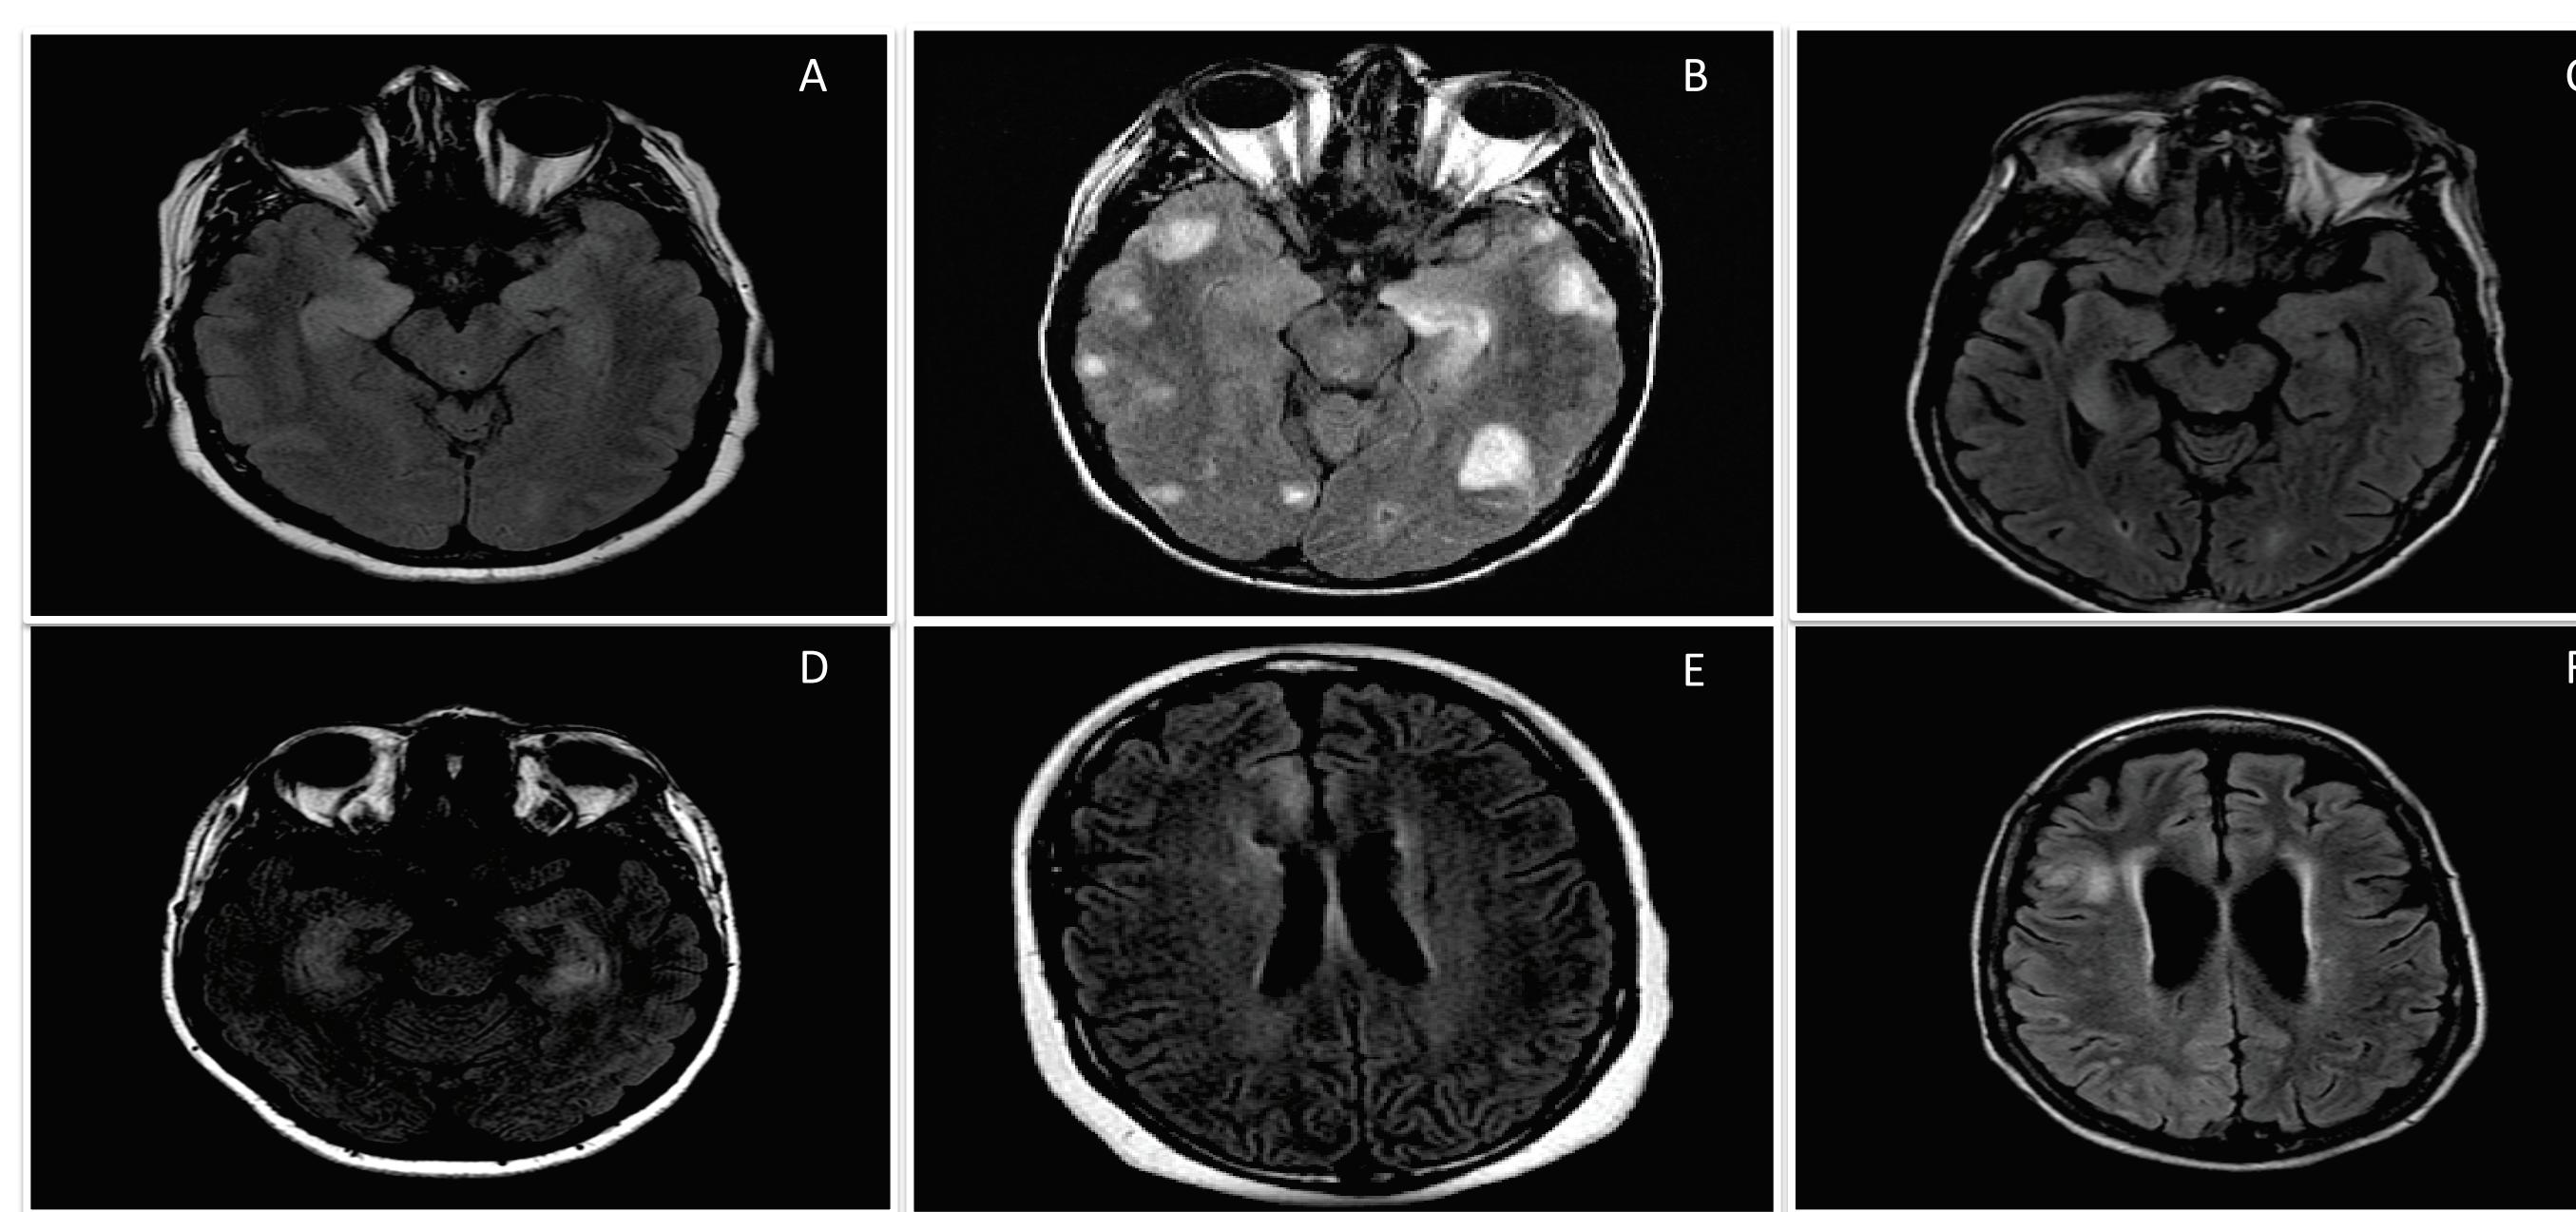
42 yo female with VGKc antibody: MRI showing bilateral temporal FLAIR hyperintensities (A); 43 yo male with VGKc antibody; MRI showing multifocal FLAIR abnormalities (B); 53 yo male with GABA_B receptor antibody: MRI depicting right medial temporal FLAIR hyperintensity (C); 32 yo male with no underlying paraneoplastic/autoimmune antibody: MRI depicting bilateral medial temporal FLAIR hyperintensities (D); 26 yo female with NMDA-R antibody: MRI depicting frontal lobe FLAIR hyperintensities (E,F).
